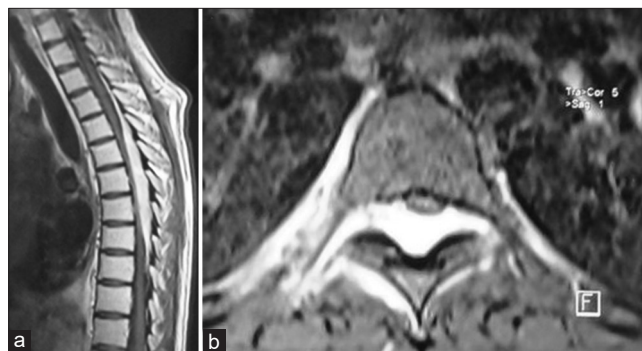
Sagittal (a) and axial (b) sections of a spinal cord magnetic resonance imaging on T1-weighted image with injection of Gadolinium showing a posterior epiduritis ranging from T5 to T10 responsible for compression of the spinal cord.
